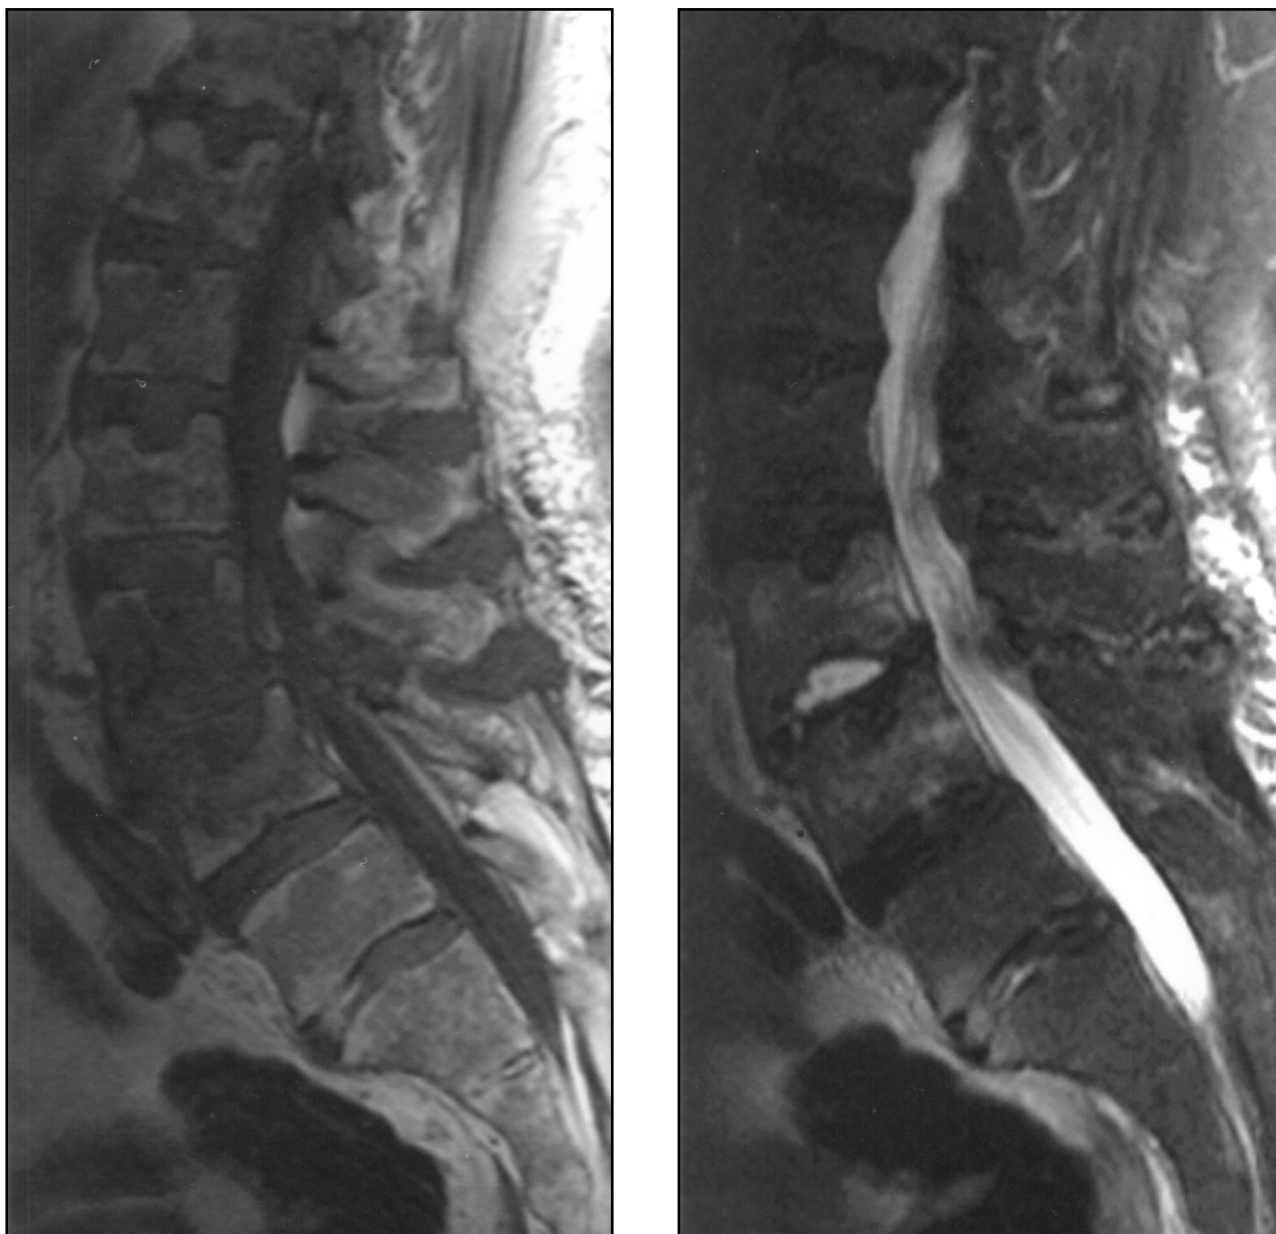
MRI of dialysis spondyloarthropathy. A) 67 year old male on hemodialysis for 11 years with no clinical or laboratory evidence of infection. The images show false positive findings for spondylodiscitis. A. Sagittal T1 weighted fast spin-echo image (600/12) shows low signal intensity in the L3 and L4 vertebrae. B) Sagittal T2-weighted fast spin echo image (5000/118) marked enhancement of the L3-L4 disc and slightly creased signal in the L3 and L4 vertebrae.
